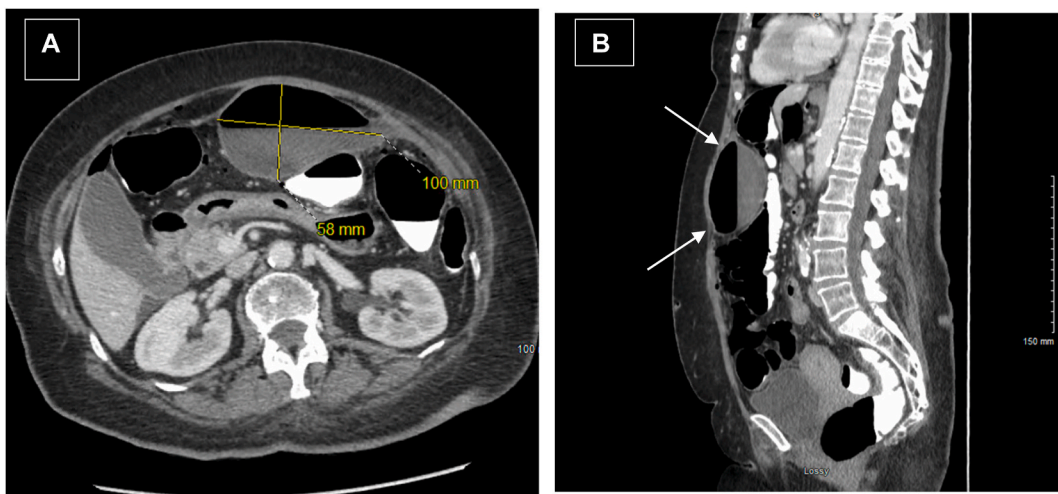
Repeat CT A/P with interval decrease in pneumoperitoneum but increase in size of the anterior abdominal wall abscess (white arrows). A) Axial view, (B) Sagittal view.
